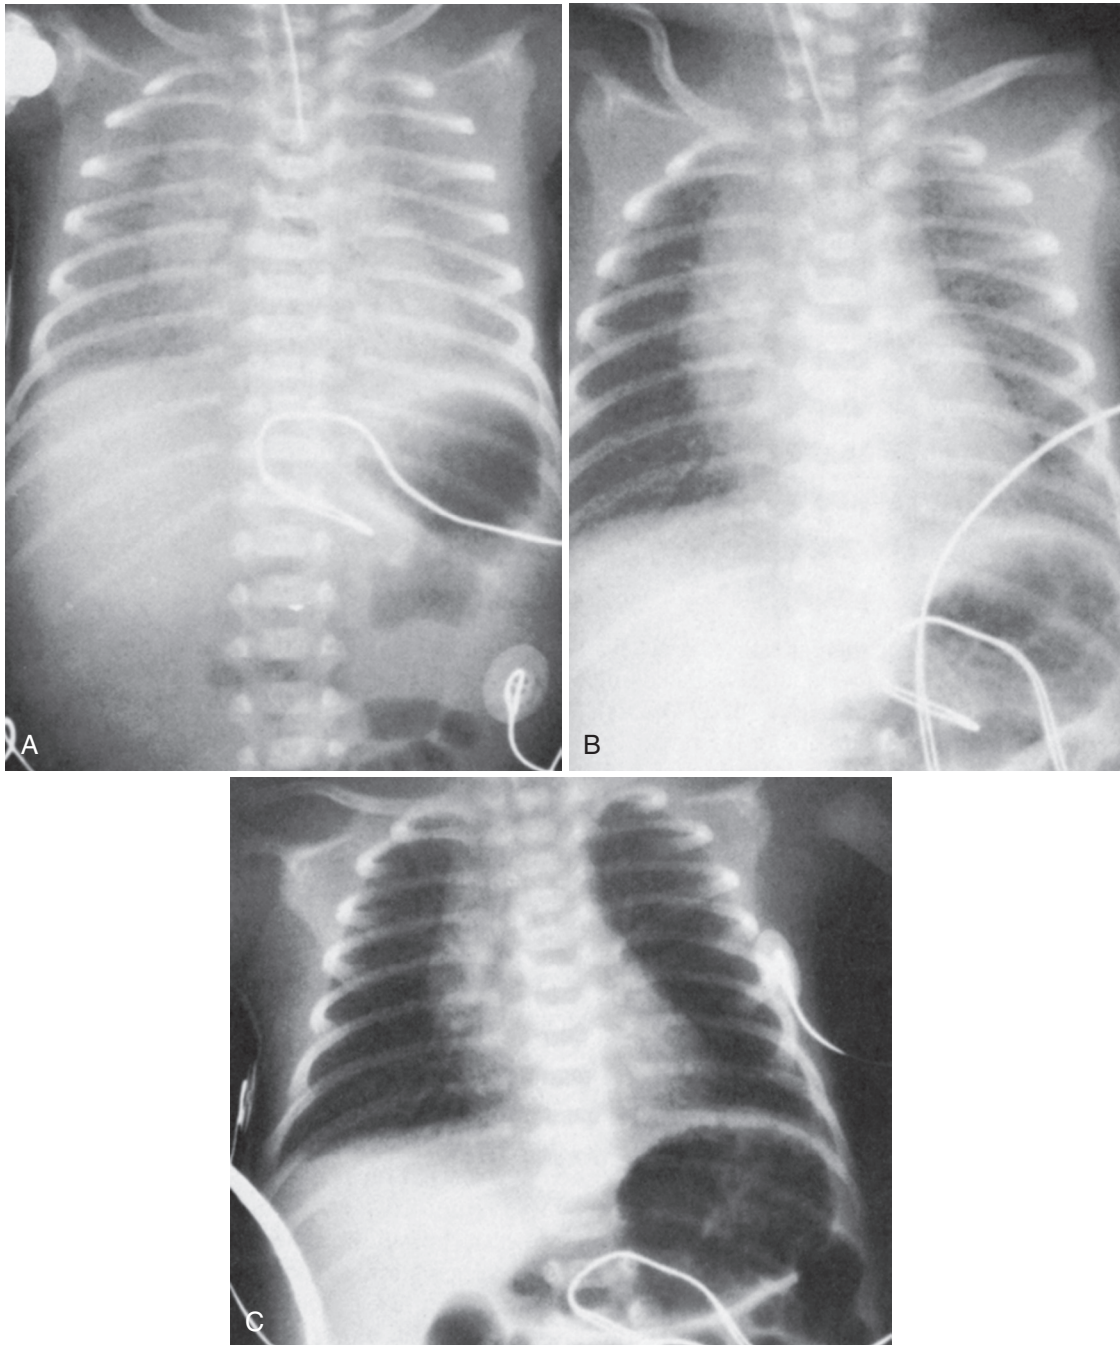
Radiographs during the first day of life for a 30-week premature infant with respiratory distress syndrome (RDS) managed with high-frequency oscillatory ventilation (HFOV) to achieve optimal mean lung volume (MLV). A, Initial mP_{aw} equal to 10 cm H₂O, fraction of inspired oxygen (F_{iO_2}) equal to 1. B, At 12 hours of age, with mP_{aw} equal to 15 cm H₂O and F_{iO_2} equal to 0.45. C, At 24 hours of age with mP_{aw} equal to 12 cm H₂O and F_{iO_2} equal to 0.28.
